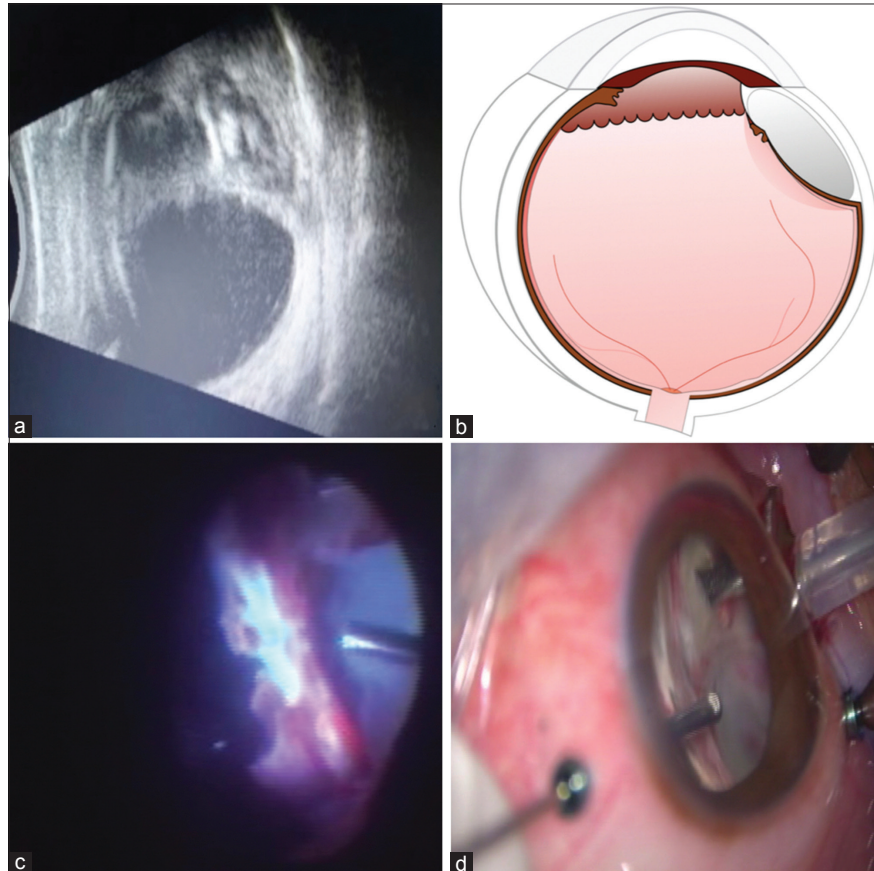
(a) Ultrasound of right eye showing hyperreflective dot and membrane echoes, (b) pictorial representation of suprachoroidal dislocated lens, (c) intraoperative view of taut separated choroid and the lens lying in the suprachoroidal space, and (d) residual lens in suprachoroidal space removed with cutter by indentation and adjacent sclera visible
